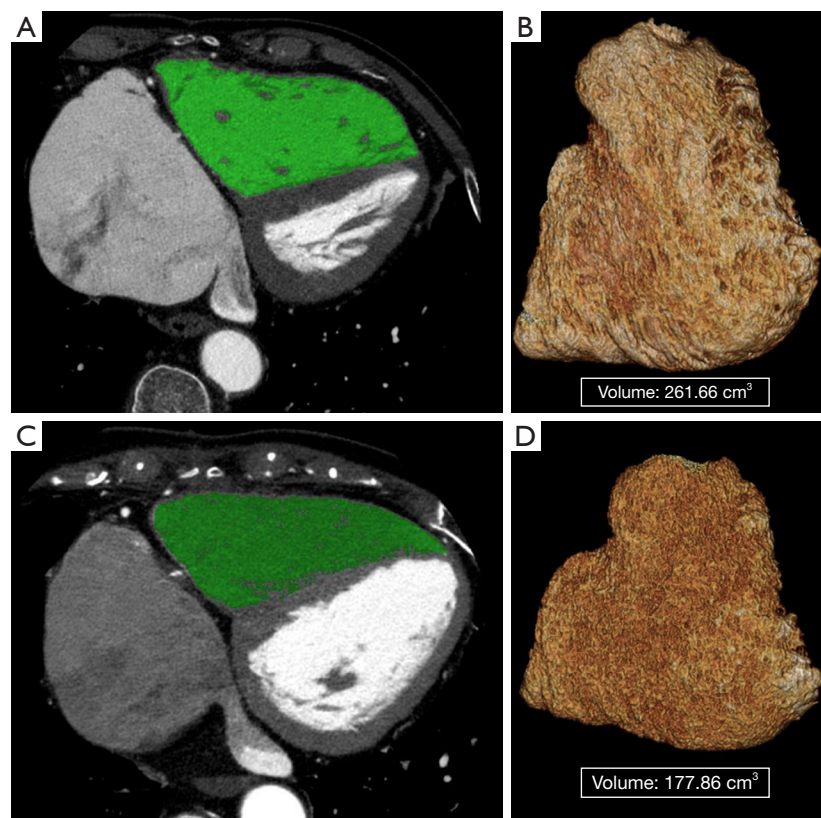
A representative case in a 73-year-old female for measurement of RV volume using cardiac CT. (A,B) The RVEDV/BSA was measured at 261.66 mL (201.3 mL/m^2) on preoperative cardiac CT, which was taken 5 days prior to the surgery. She had been diagnosed with prosthetic mitral valve dysfunction, native aortic valve steno-regurgitation, and severe TR. She subsequently underwent tricuspid valve repair using an annuloplasty ring, along with a redo-mitral valve replacement and aortic valve replacement. (C,D) Postoperative cardiac CT showed a decrease in RV volume [RVEDV 177.86 mL (134.7 mL/m^2)], resulting in postoperative RVEDV change of -33.0% . On postoperative follow-up echocardiography at 7 months, she had a moderate residual TR and right ventricular systolic pressure of 42 mmHg. (A,C) Axial CT images (RV cavity in green) and (B,D) 3-dimensional volume rendering images depict RV volume measurement. BSA, body surface area; CT, computed tomography; EDV, end-diastolic volume; RV, right ventricle; TR, tricuspid regurgitation.
